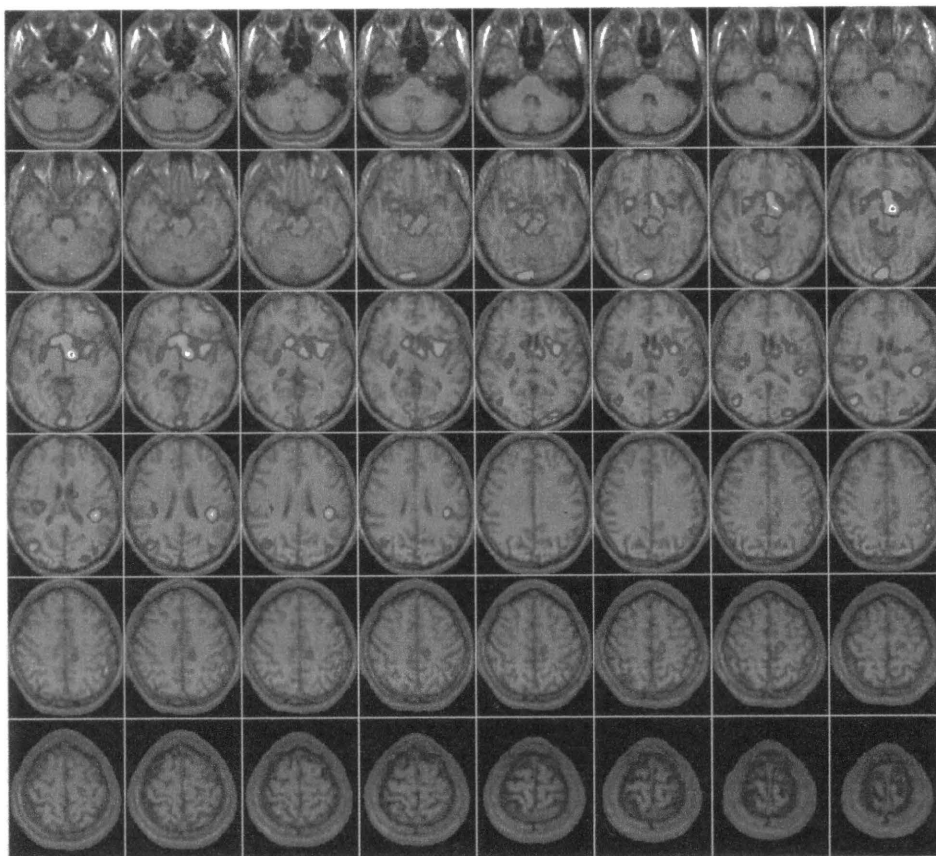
ECD-SPECT eZIS 解析による脳血流所見
